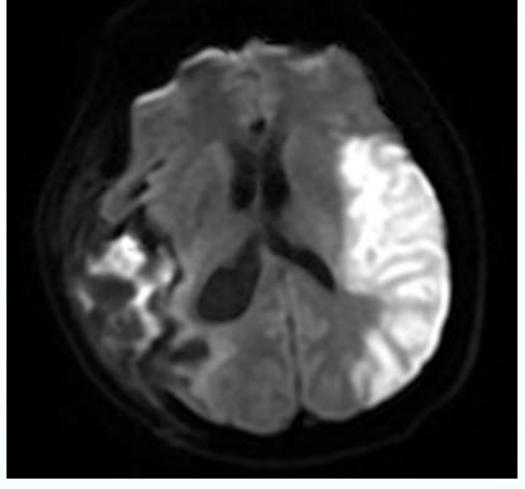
MRI demonstrates previous right MCA stroke as well as acute left MCA stroke
